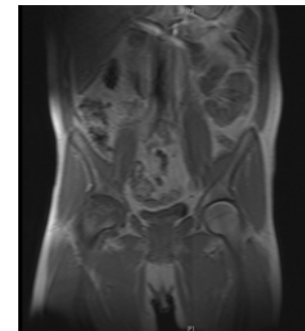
Magnetic resonance imaging showing AVN of right femoral head
